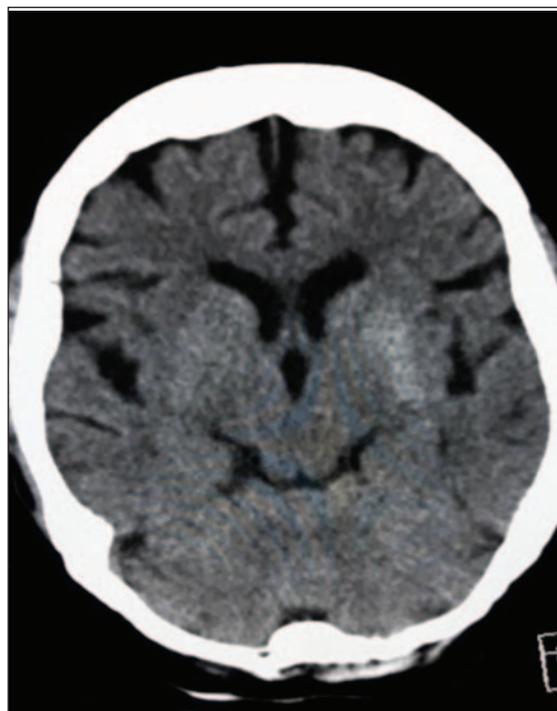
CT study showing a hyperdense lesion in the left basal ganglia in a patient with NK-HCB.
